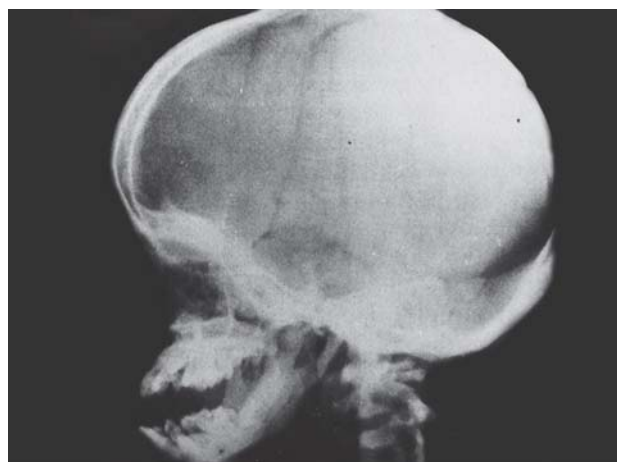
Lateral cephalometric radiography of the patient
